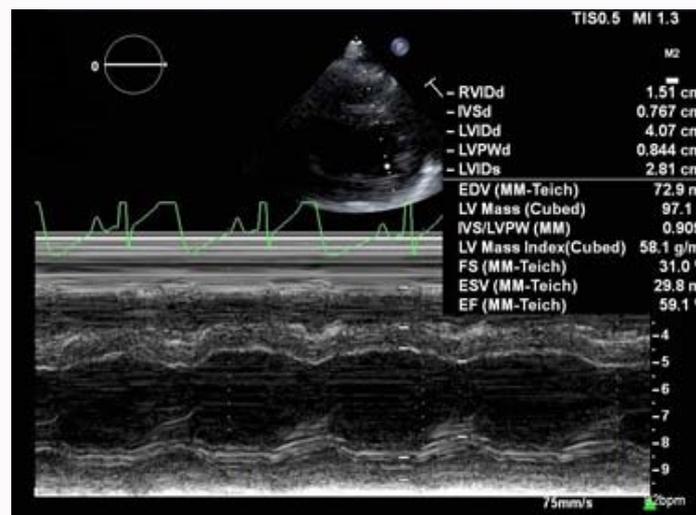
Parasternal short axis M Mode image of the mid-cavitary portion of the left ventricle on the day following transfer to our institution demonstrating normalization of left ventricular systolic function with an estimated Ejection Fraction (EF) of 59.1%, and a shortening fraction of 31.0%.
